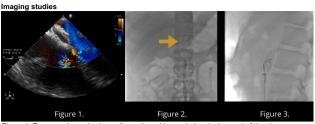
Transesophageal echocardiography guidance during deployment of the closure device. Figure 2. Visualization of the device in abdominal aorta at the level of renal arteries in Biplane X-ray, Figure 3. Endoyascular retrieval of the embolized device.
